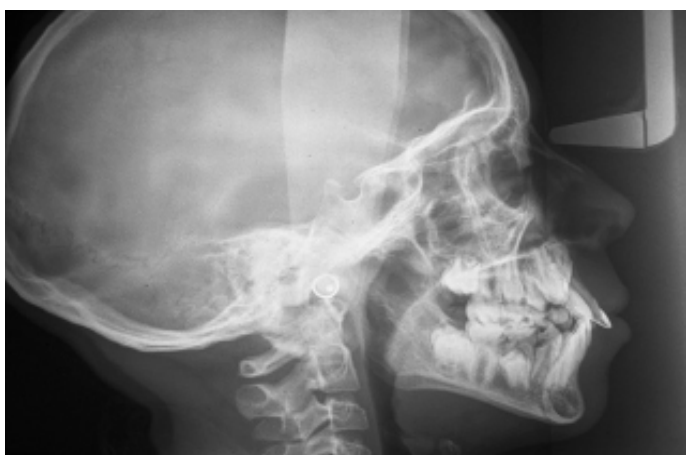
Pretreatment lateral cephalometric radiograph revealed anomalous sagittal position of the impacted incisor.
